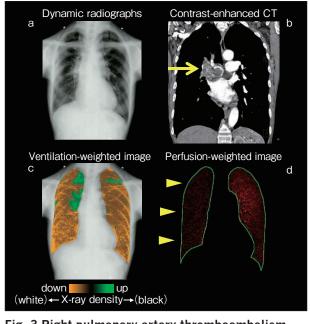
Right pulmonary artery thromboembolism (75 years old, female) a: Dynamic X-ray analysis image b: Contrast-enhanced CT image
